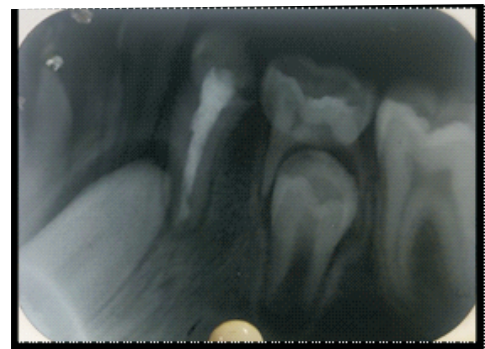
Periapical radiograph of #44 post-operative after one-month follow-up showing an increase in dentinal root thickness.
